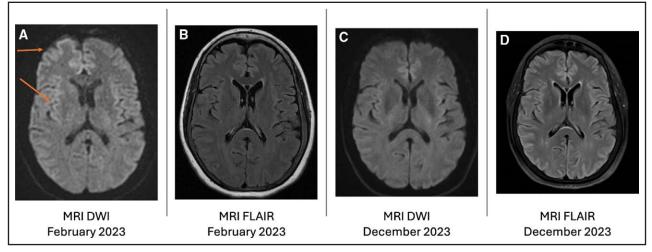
A 52-year-old woman with a history of epilepsy presented with mild dysarthria and mild weakness of the left arm. Axial diffusion-weighted imaging (DWI; A) shows cortical ribboning within the right frontal and right insular cortices and to a lesser extent the left paramedian frontal cortex consistent with a postictal state. Axial FLAIR (fluid attenuated inversion recovery) (B) shows no obvious abnormal signal. Follow-up DWI (C) and FLAIR (D) obtained 10 months later show resolution of cortical ribboning on DWI with unchanged FLAIR signal.
